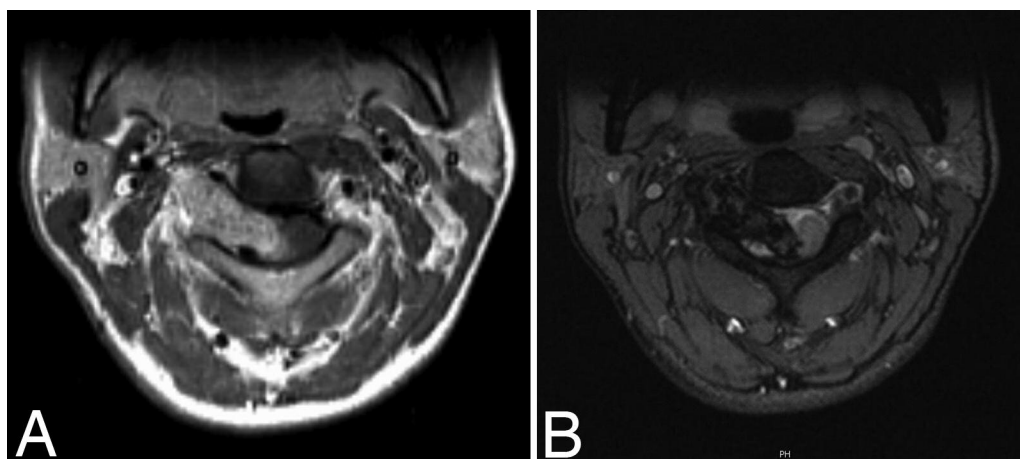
Axial MR images showing a C2–3 intra–extradural lesion hyperintense after T₁-weighted gadolinium-enhanced imaging (A) and hypointense after T₂-weighted spin echo imaging (B).
